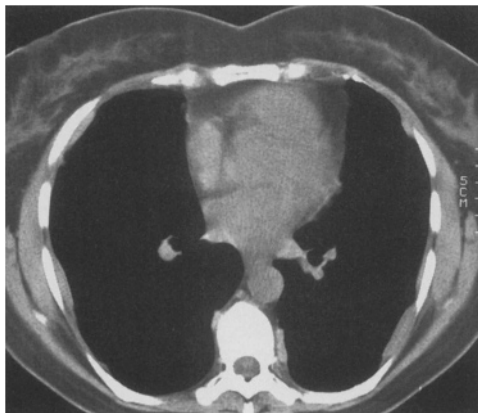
CT scan : typical tableland shaped bilateral pleural plaques
